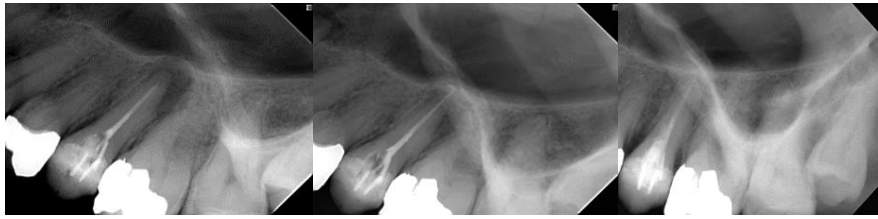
a) Maxillary left second premolar radiograph showing the previous RCT with gutta-percha, b) retreatment of the canal with CC, c) 4-year recall radiograph.
